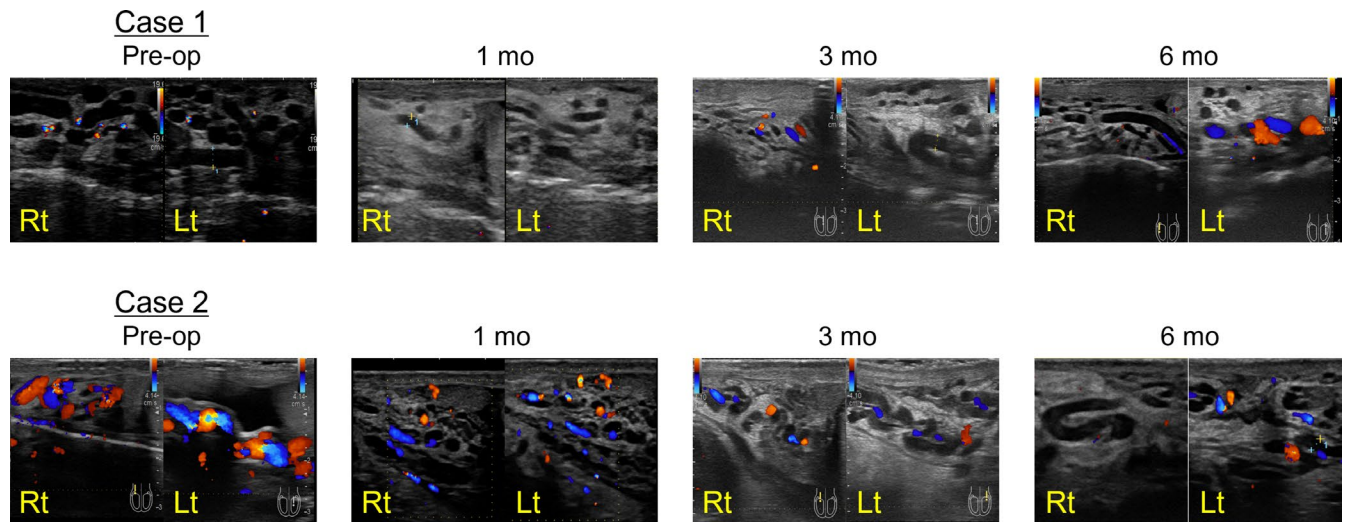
Temporal changes in Doppler ultrasound findings of varicocele before and after surgery. Serial Doppler ultrasound images of the bilateral pampiniform plexus before surgery and at 1, 3, and 6 months postoperatively. Images were selected from comparable anatomical levels where venous dilatation was most prominent, with the patient standing during the Valsalva maneuver. Initial improvement at 1 month was followed by recurrent venous dilatation during follow-up. Scale bars are shown in each panel.
